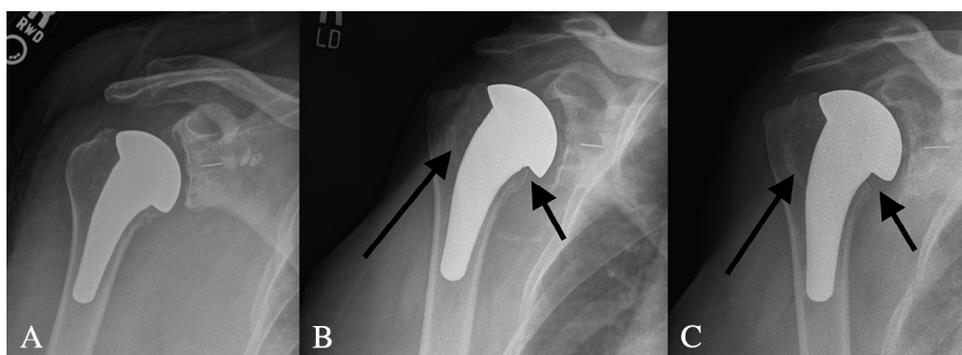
(A) Anatomic press-fit short stem, initial postoperative radiograph. (B) Anatomic press-fit short stem, 1.5 years postoperatively with radiolucency (long arrow) and medial osseous resorption (short arrow). (C) Anatomic press-fit short stem, 5 years postoperatively with progressive radiolucency (long arrow) and medial osseous resorption (short arrow).
